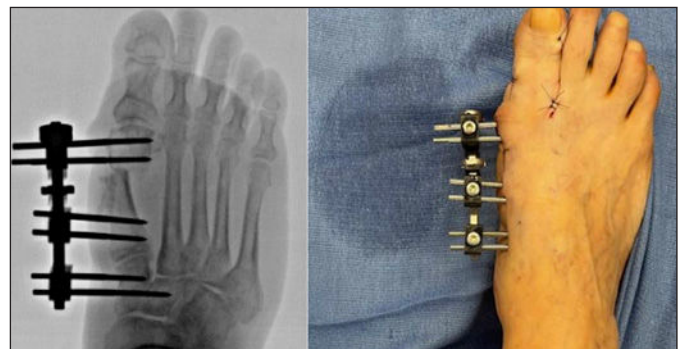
Intraoperative X-rays and picture
